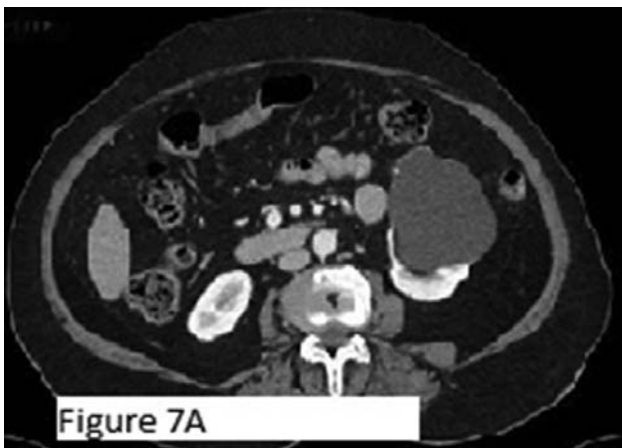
Axial contrast enhanced CT abdomen image showing left renal cyst. 7B: About 70 cc fluid was initially aspirated from this cyst and contrast was injected which showed no communication with pelvicalyceal system. Minimal amount of absolute alcohol was also injected.
